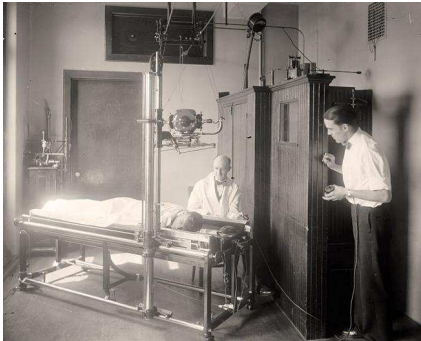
Newer X-ray Devices and Radiographs (Hand, Lungs)
